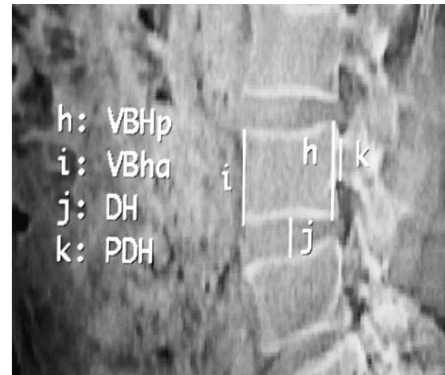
Lateral View of Lumbar Spine Dimension Labels, Zhou, S.H., I.D. McCarthy, A.H. McGregor, R.R.H Coombs, and S.P.F. Hughes. "Geometrical Dimension of the Lower Lumbar Vertebrae-Analysis of Data from Digitised CT Images ." *European Spine Journal. 9.* (2000): 242-248. Print, Used under fair use, 2015.
